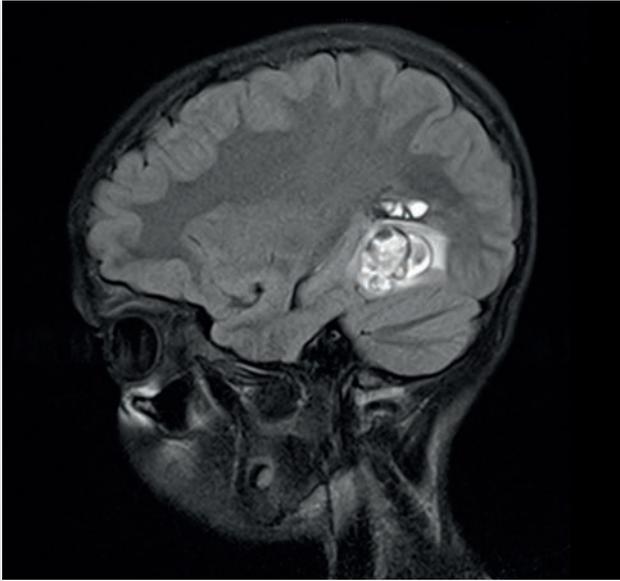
12-year-old patient with acute symptomatic bleeding (bright areas in this MR image) presenting with various neurological deficits)
